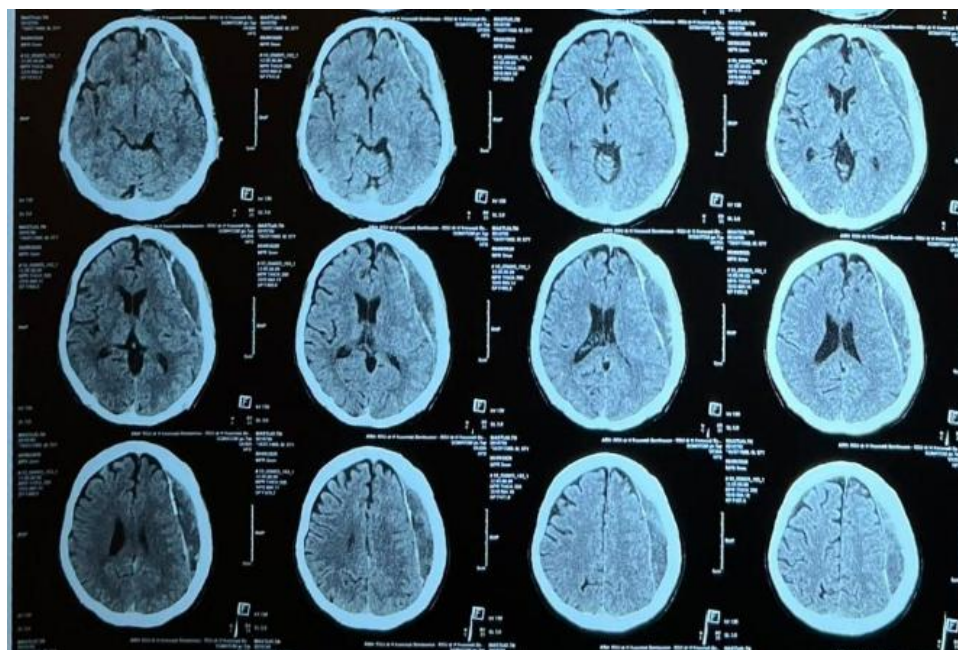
Non-contrast head CT demonstrating a left frontotemporal hypodense lesion, suggestive of late subdural hemorrhage
